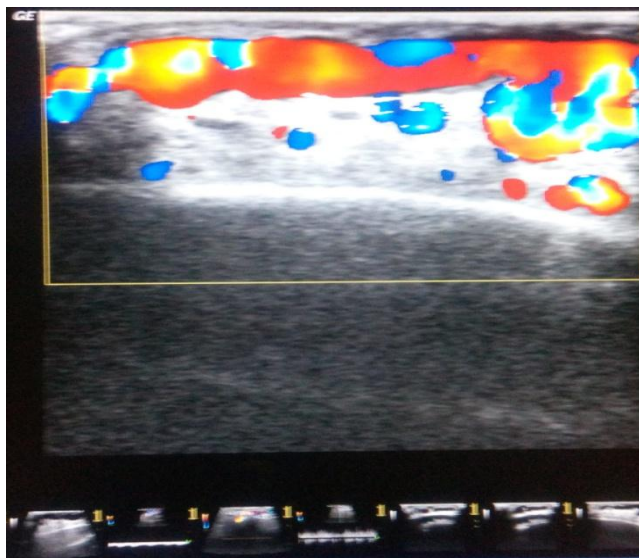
Ultrasound Doppler image showing multiple, dilated, superficial vascular channels in frontoparietal region of scalp.
